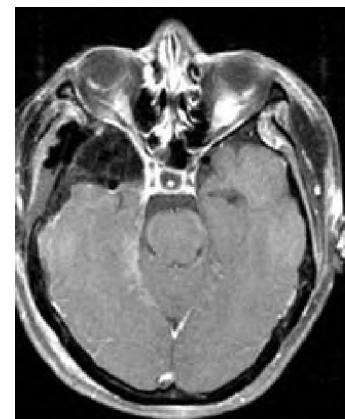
Postoperative magnetic resonance imaging showing resection with fat and tensor fascia lata used to repair cranial base defect.
